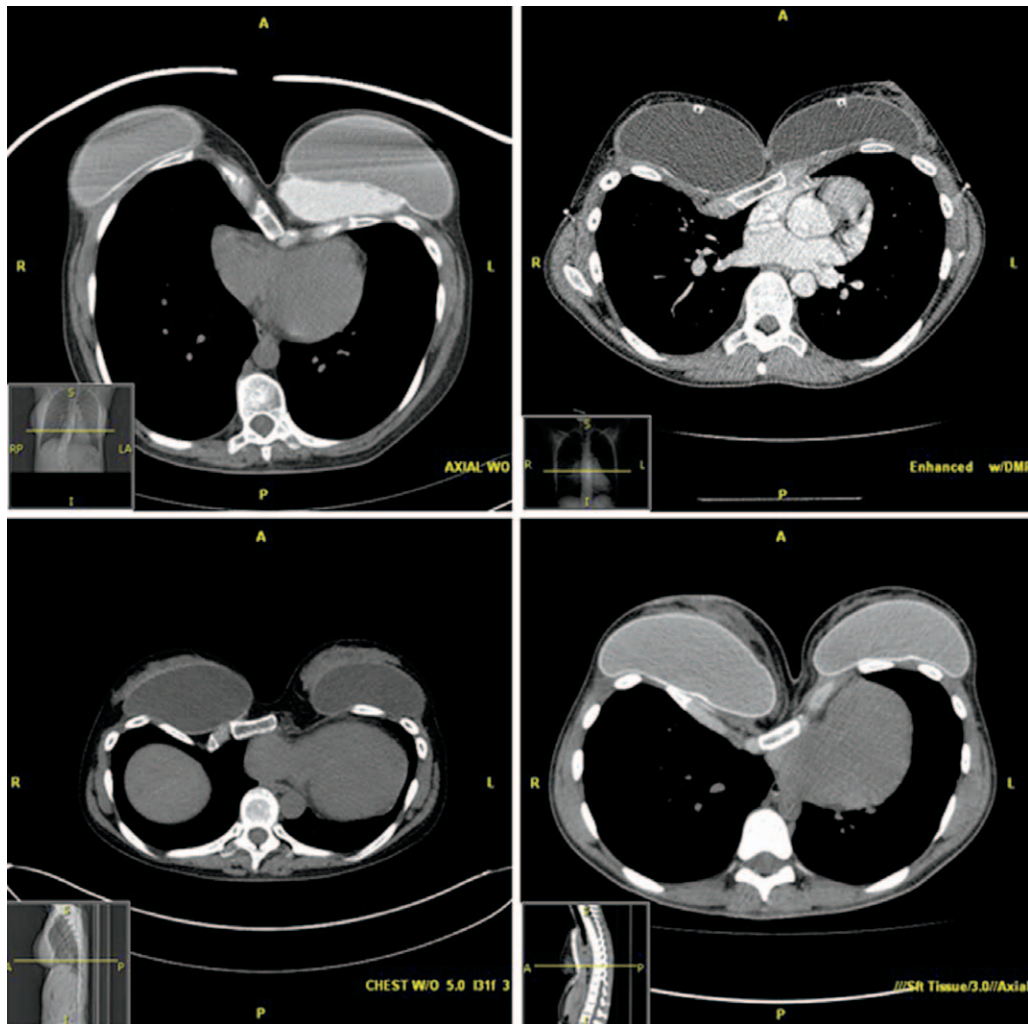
Thoracic computed tomographic scans of patients with pectus excavatum noting deformity and prior breast implants and a custom chest wall prosthesis (*above, left*). Used with permission of Mayo Foundation for Medical Education and Research.
